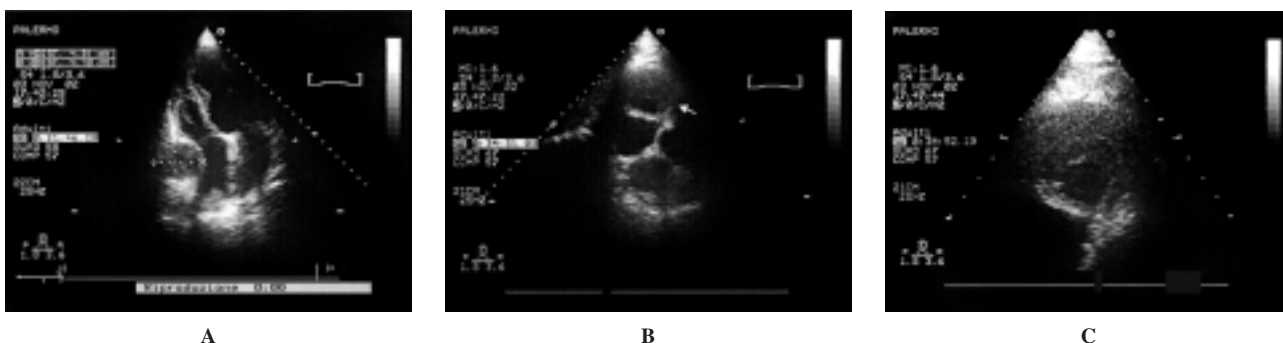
Transthoracic echocardiography (A: 4-chamber view; B: subcostal view; C: detail of the subcostal view). Note the presence of a round structure (4.5 cm in diameter), adjacent to the right heart and compressing the right atrium and ventricle. The mass has an echo-free center with an echogenic layer lining the perimeter, suggestive of thrombus.
